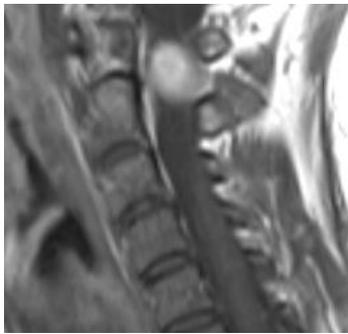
Pre-operative MRI - Intradural extramedullary tumour.
